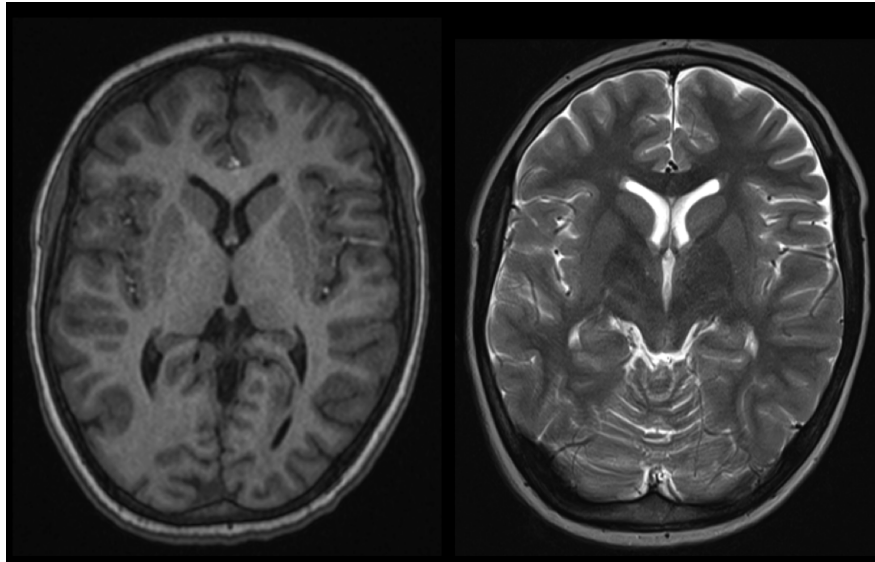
Standard T1-weighted and T2-weighted MRI. Axial slices of T1-weighted (left) and T2-weighted (right) MRI sequences showing grey and white matter. White matter appears hyperintense on T1-weighted and hypointense on T2-weighted images. Cerebrospinal fluid is hypointense on T1-weighted and hyperintense on T2-weighted images. (MRI: magnetic resonance imaging)
